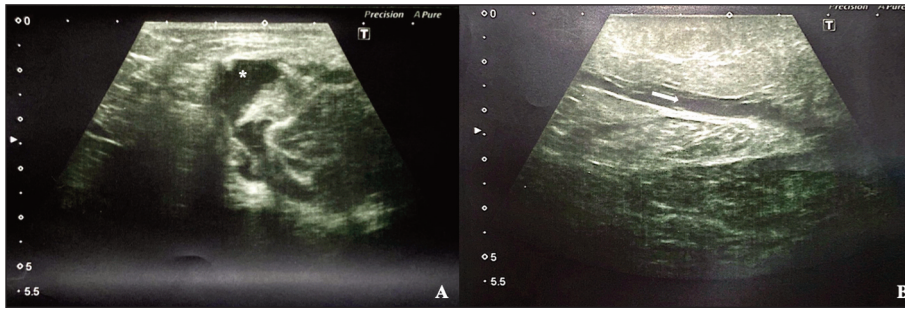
A) Transverse view of the popliteal fossa. Note the image of the ruptured Baker's cyst (asterisk). B) Longitudinal view of the right calf. The longitudinal sonogram shows the Baker's cyst (arrow) which extends caudally.
